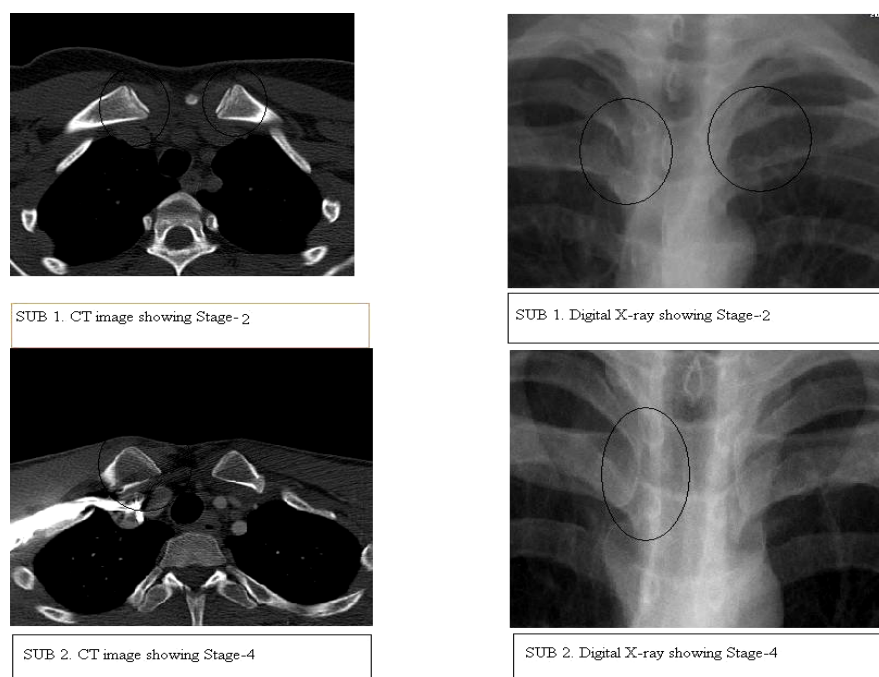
Subjects: 1 and 2 show same staging results on CT as well as DR.
